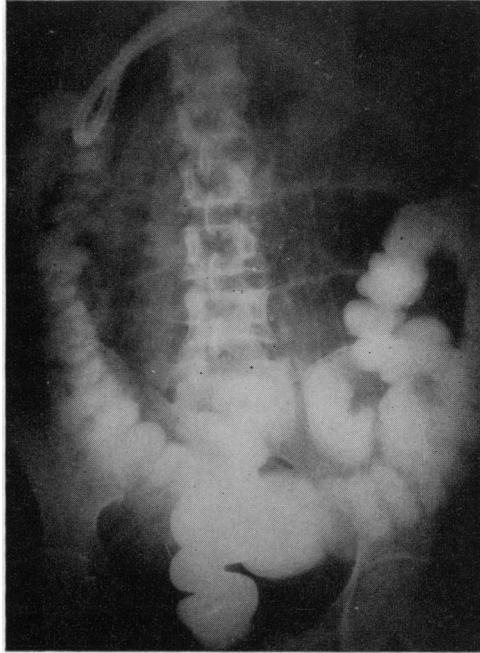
Roentgenogram of abdomen following barium enema showing dilated loops of small intestine and ptosis of transverse colon. The diagnosis of paraduodenal hernia could not be made from this film.
